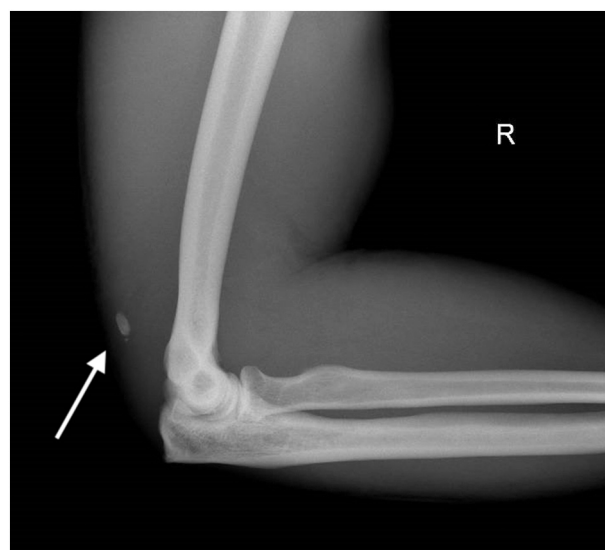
Lateral X-ray of the injured elbow at the presentation. A bony avulsion fragment can be seen (arrow).
